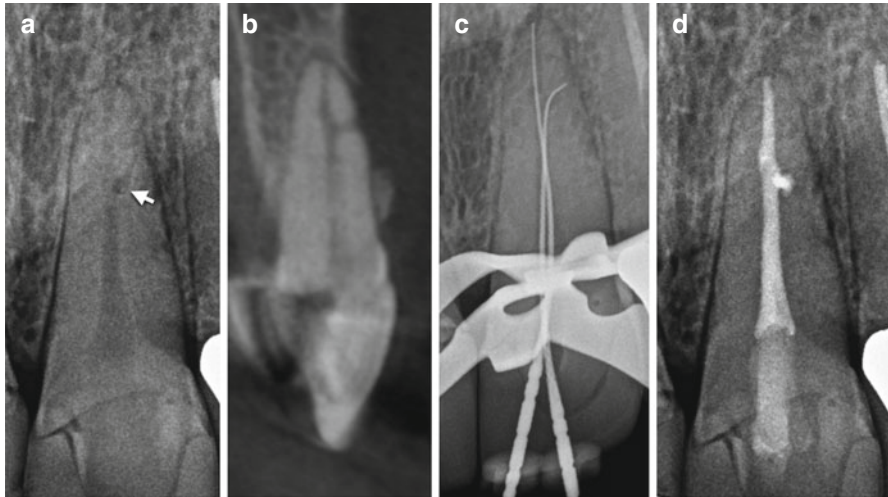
Preoperative periapical radiograph of a maxillary left central incisor (note the radiolucent area superimposed on the root in the apical third [white arrow]) (a). The sagittal CBCT slice demonstrates the presence of an accessory canal with a buccal portal of exit (b). A mid-treatment periapical radiograph demonstrates an endodontic file placed in the main root canal system as well as the accessory canal (c). Post-endodontic periapical radiograph demonstrates proper management of both the main root canal system and the accessory canal (d)
